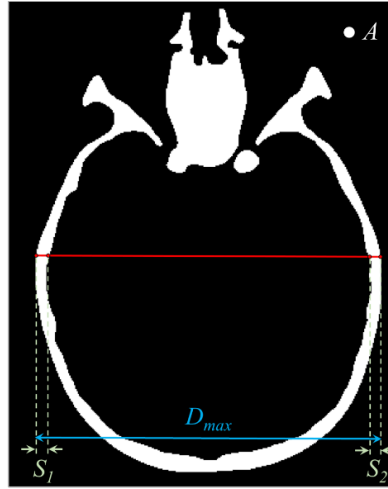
Mask of the CT slice in which the measured quantities being compared in transverse plane. A: area of skull section (white pixels); D_{max} : maximum longitudinal diameter; S_1 and S_2 : skull thicknesses at D_{max} .
